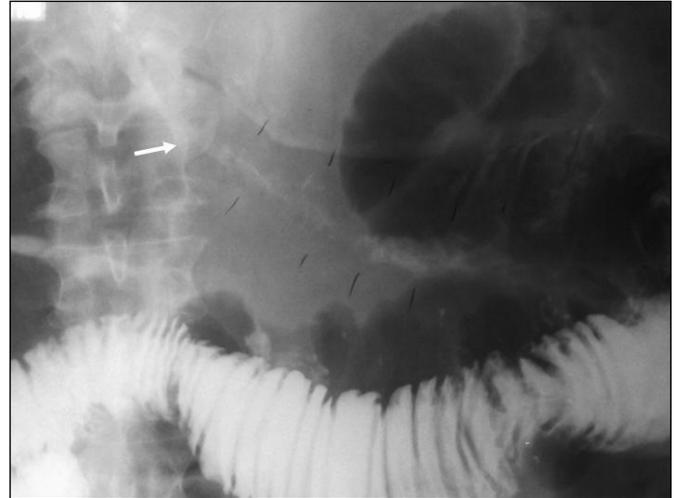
Contrast radiographic small bowel follow-through, demonstrating a focal narrowing of a loop of small bowel (string sign).
